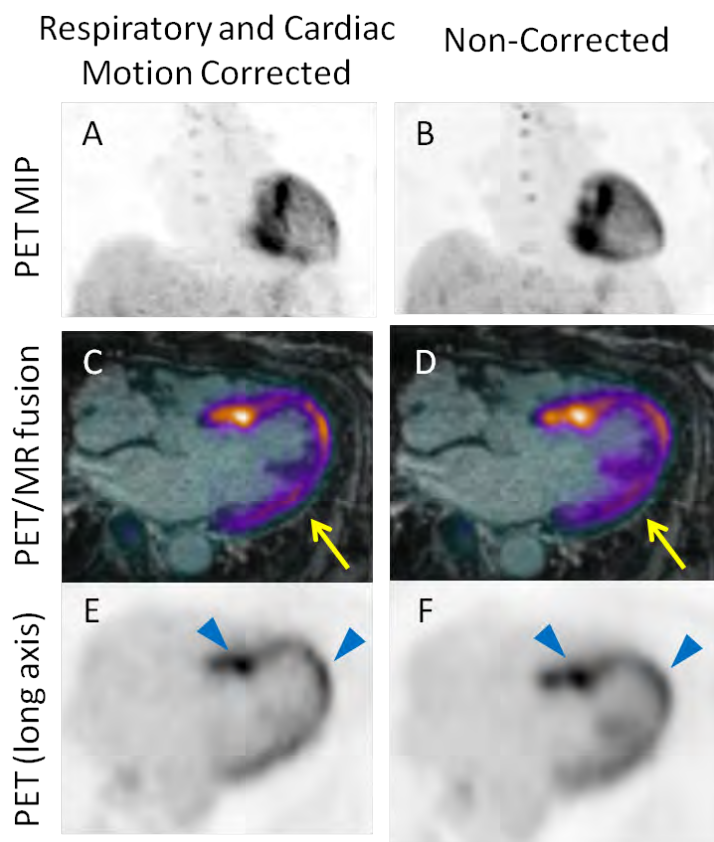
18F-FDG PET images in a patient with cardiac sarcoidosis. Maximum intensity projections (A-B), long-axis PET fusion with contrast-enhanced MR (C-D), and long-axis PET in the same plane (E-F). Application of the proposed MR-based respiratory and cardiac motion correction to the PET data (left) reduces blurring of the myocardium compared to PET images without correction (right), particularly in the lateral wall (arrow), and increases the contrast of hotspots compared to diffuse uptake in the myocardium (arrowheads).
